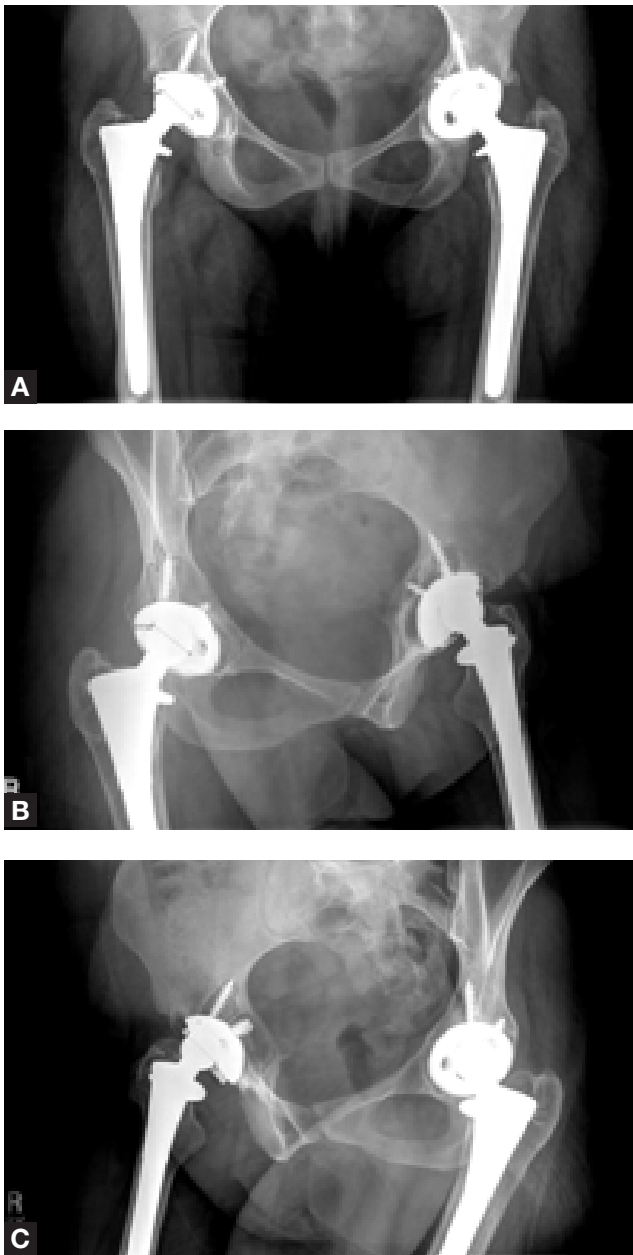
Anteroposterior (A), right anterior oblique (B), and right posterior oblique (C) x-rays of female patient's pelvis with bilateral uncemented hip arthroplasties, both showing evidence of polyethylene wear and osteolysis. On the right, there is significant periacetabular osteolysis, which has been outlined, and the transverse diameter of the femoral head has also been measured. At surgery, the osteolysis was shown to be posterior and medial, and the measured area of osteolysis was larger on the anteroposterior and right posterior oblique x-rays.
